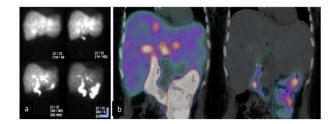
Cholangiogammagraphy with 99mTcmebrofin; (a) the biliary tract is observed from minute 10, with transit to the intrahepatic biliary tract, common bile duct (CBD) and choledochus at minute 15, which are prominent due to dilatation and statis of bile, with subsequent flow to the gastric cavity and intestine, which is visualized from minute 30; the prominence of the CBD persists upto 60 minutes presenting greater activity than in the liver; (b) single photon emission tomography (SPECT/CT) which corroborated dilatation of the biliary tract, bile reflux towards the CBD and stomach.
